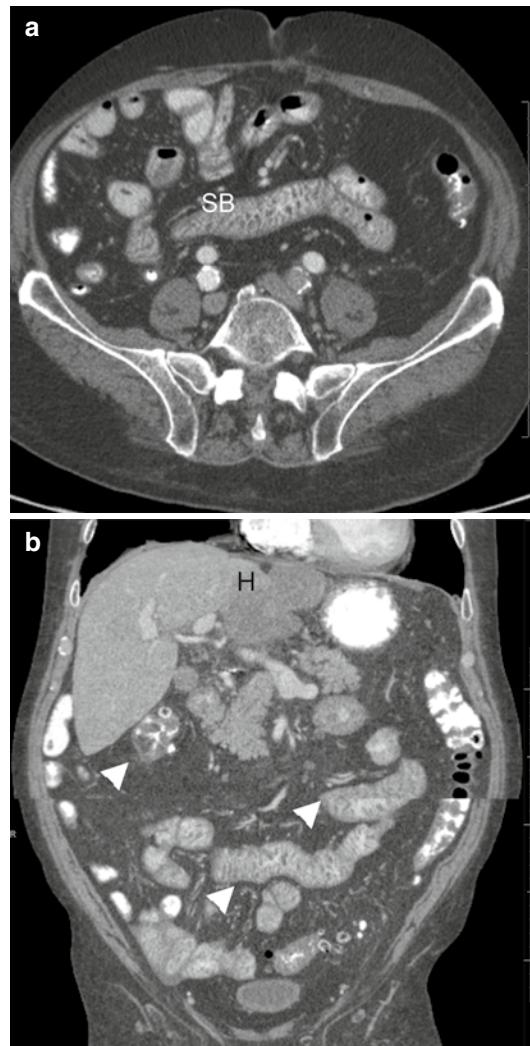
Enteritis due to bevacizumab and erlotinib. An 82-year-old male with hepatocellular carcinoma. The patient had failed sorafenib therapy and was treated with 10 cycles of bevacizumab and erlotinib. (a) Axial CT shows submucosal edema of the small bowel (*SB*). (b) Coronal CT better shows the extent of enteritis and colitis (arrowheads). *H* Hepatocellular carcinoma
